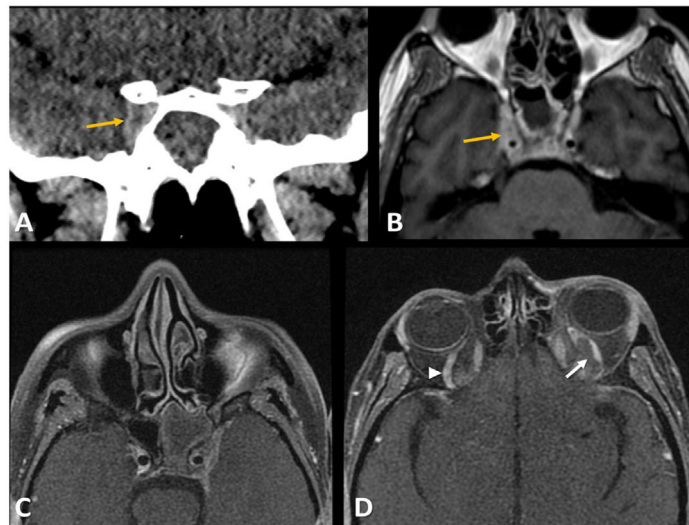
Cavernous Sinus Thrombosis: (A) Coronal enhanced-CT, brain window, and (B) post-contrast T1WI shows sphenoid sinus opacification and cavernous sinuses asymmetry, due to enlargement of the right side (arrows), which presents a convex contour, suggestive of thrombosis. On CT, filling defects on the right cavernous sinus are also seen, although less evident on MRI, due to thrombus high T1-signal. Axial post-contrast fat-saturated T1WI in two levels (C and D) in a different patient demonstrate left sphenoid sinus filling and mucosal thickening, associated to asymmetric enlargement, convex contour and enhancement of the lateral margin of the left cavernous sinus, as well as enlargement and partial occlusion of the ipsilateral superior ophthalmic vein (white arrow; arrowhead showing the normal right superior ophthalmic vein), in keeping with cavernous sinus thrombosis, probably due to retrograde spread.
